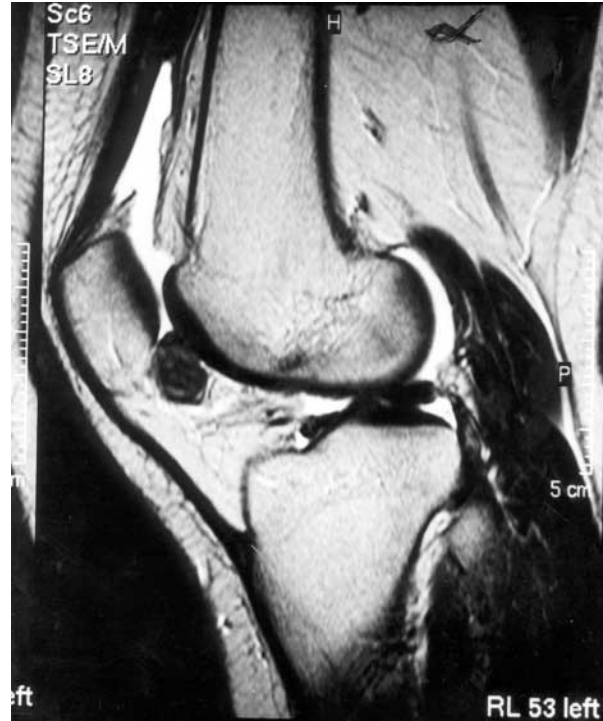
Case 4: MRI of the neoplasm (sagittal T1-weighted view).
